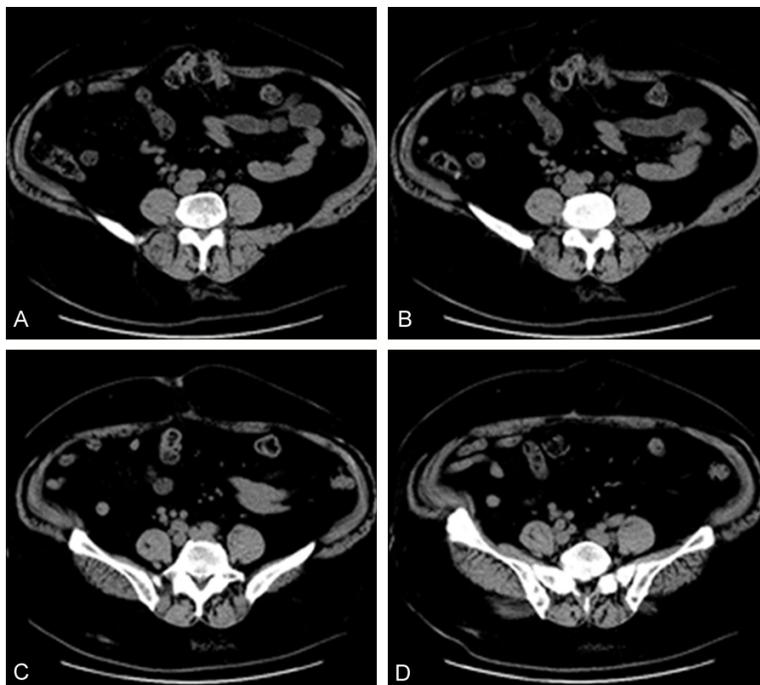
CT image Image of a 56-year old Russian male with a 30-year history of hypertension and highest recorded blood pressure of 210/120 mmHg. The patient had a history of diabetes and coronary heart disease for more than 10 years and had hepatitis C infection for the last 5 years. His blood pressure was in control; he had normal liver function and was receiving oral Adalat and aspirin treatment. Laparoscopic left renal cystectomy was performed 3 years ago. The diameter of the patient's hernial ring was 25 cm and volume of the abdominal wall mass was 20 cm * 30 cm. CT examination showed that the lower edge of the hernia ring was close to the pubic symphysis and bladder. A, B: Umbilical hernia, visible intestine and omentum shadow through the umbilical defect, local intestinal dilatation and free ascites in abdominal cavity, and obvious fat infiltration of rectus abdominis. C, D: Left semilunar hernia and expanded intestinal canal.
